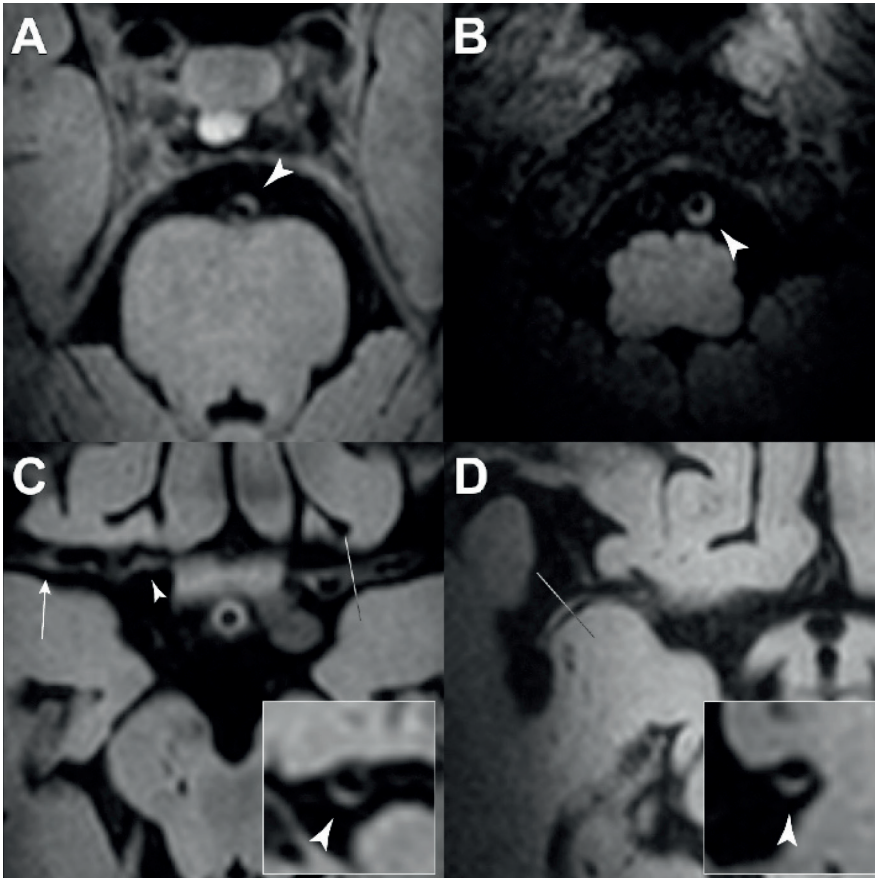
A 79-year-old male patient included with a history of coronary heart disease. On T₁-MPIR-TSE vessel wall MRI multiple lesions are identified (A-D). A) Vessel wall lesion of the basilar artery (arrowhead). B) Vessel wall lesion of the distal left vertebral artery (arrowhead) with normal right vertebral artery. C) Bilateral M1 vessel wall lesions (arrow, and arrowhead in sagittal MPR in enclosed panel). Also, note lesion in the proximal right A1 segment (small arrowhead). D) Vessel wall lesion in the proximal right M2 segment.
